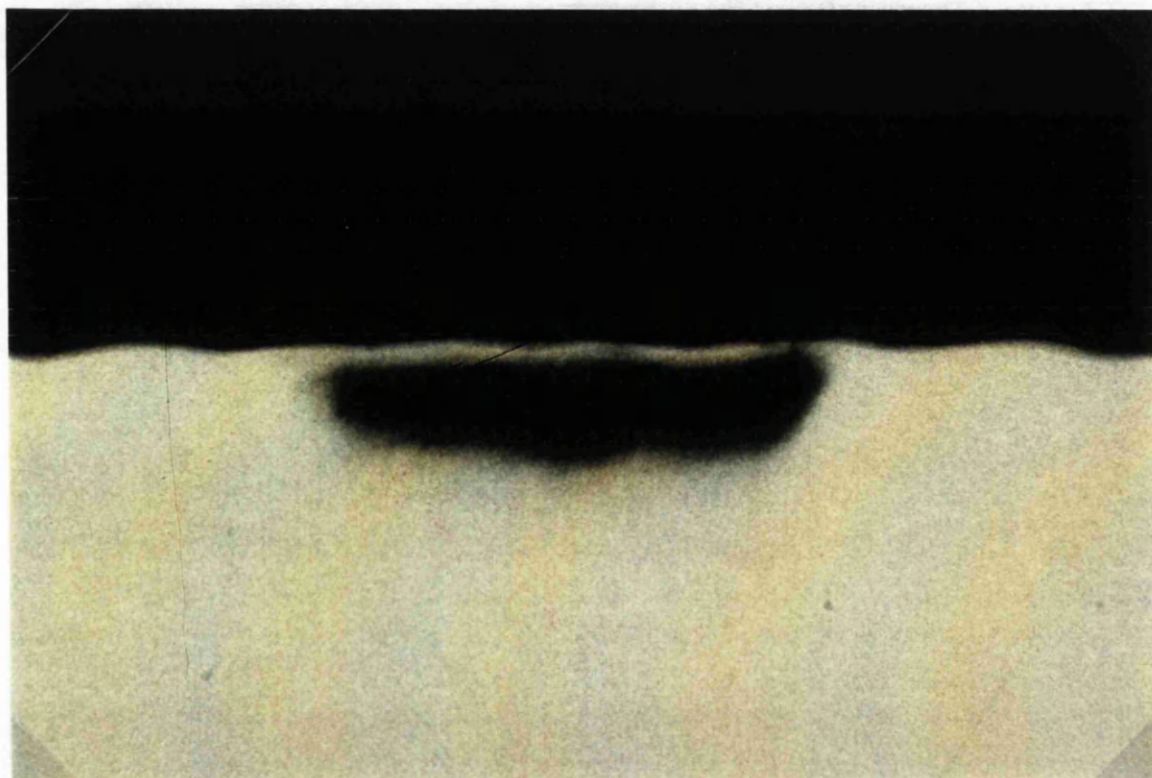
Radiographic image of a subsurface caries lesion
